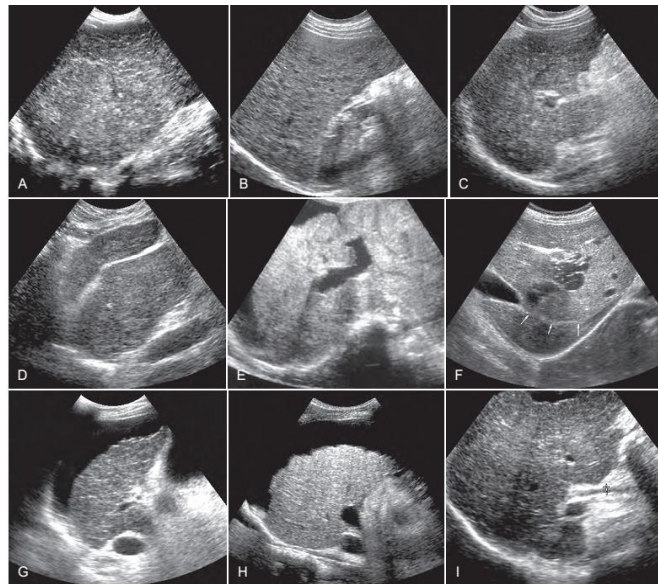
Ultrasound images of cirrhotic liver show A, Coarse parenchyma and innumerable tiny, hyperechoic nodules. B, Coarse parenchyma and innumerable tiny, hypoechoic nodules. C, Coarse parenchyma and surface nodularity. D, Sagittal image showing an enormous caudate lobe. E, Transverse sonogram shows the right lobe is small with enlarged the left lateral segment. G and H, Small, end stage liver with surface nodularity, best appreciated in patient with ascites. I, liver contour varies greatly. (Carol, 2011)
